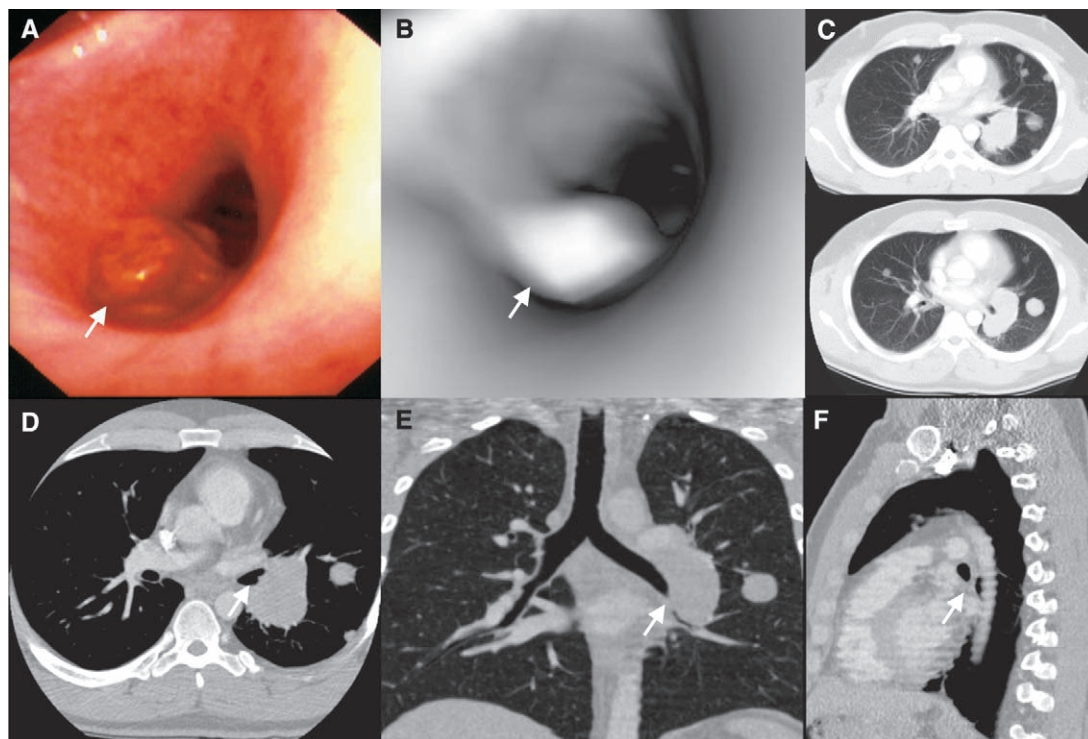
Endoluminal lesion obstructing superior segment of left lower lobe in 30-year-old man who had metastatic melanoma FB (A), VB (B), and SHR-CT axial (D), coronal (E) and sagittal sections (F) all visualized this lesion (white arrow); however, this lesion was not appreciated on consecutive conventional CT sections (C). (Courtesy of US government.)
